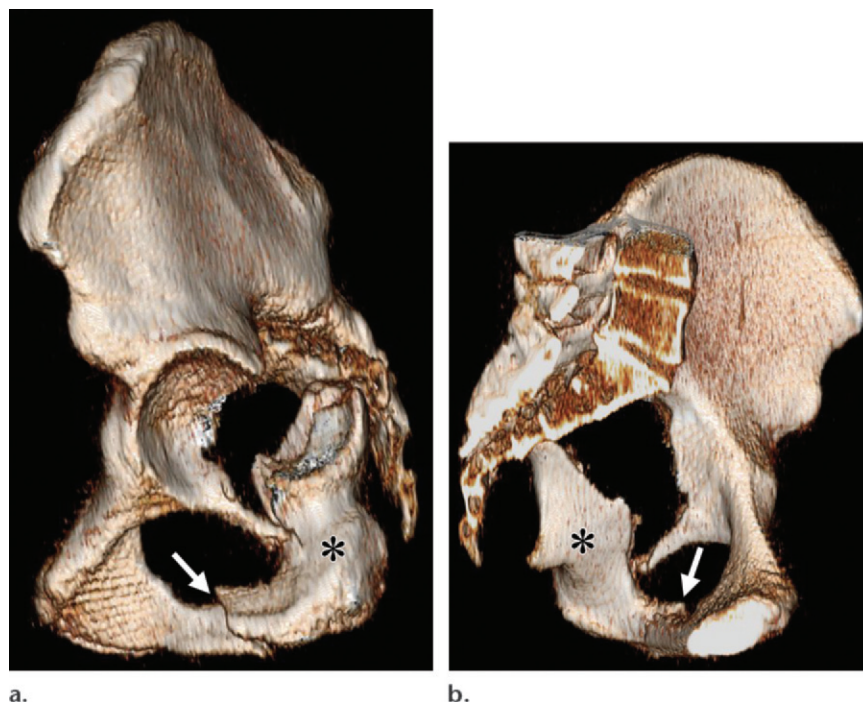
Posterior column acetabular fracture in a 45-year-old man. Lateral (a) and medial (b) 3D surface-rendered CT images of the acetabulum show a markedly displaced fracture separating the posterior column (*) from the sciatic buttress. As with other column fractures, a fracture (arrow) runs through the ischiopubic ramus. A mild step artifact is also seen, a result of the use of 2.5-mm source images for 3D surface rendering.
